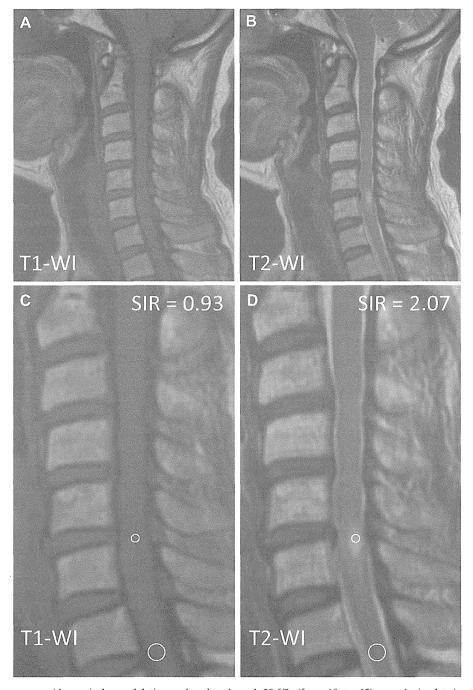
A 59-year-old woman with cervical spondylotic myelopathy showed 28.6% (from 10 to 12) neurologic deterioration at follow-up. (A) mid-sagittal T1-weighted MRI, (B) mid-sagittal T2-weighted MRI, which shows intramedullary increased signal intensity at C5–C6 level. (C) SIR is calculated by the mid-sagittal increased cord signal intensity (smaller round) / mid-sagittal normal cord signal intensity at the C7-T1 disc level (larger round) on T1-WI. (D) SIR on T2-WI is calculated using the same equation on the same lesion on T1-WI.MRI, magnetic resonance imaging; SIR, signal intensity ratio; WI, weighted image.
